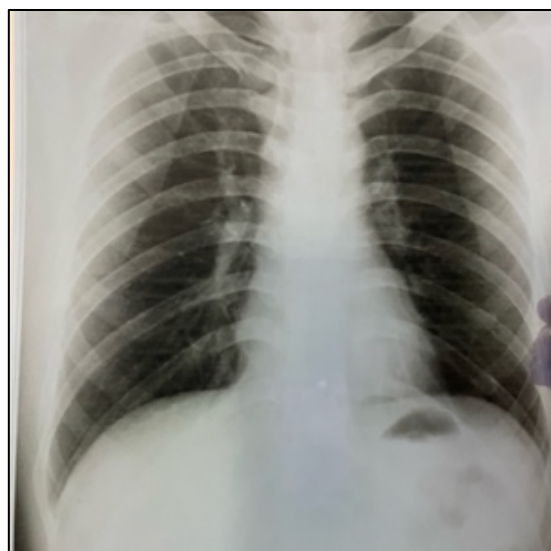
Chest X-ray During ICU Care
